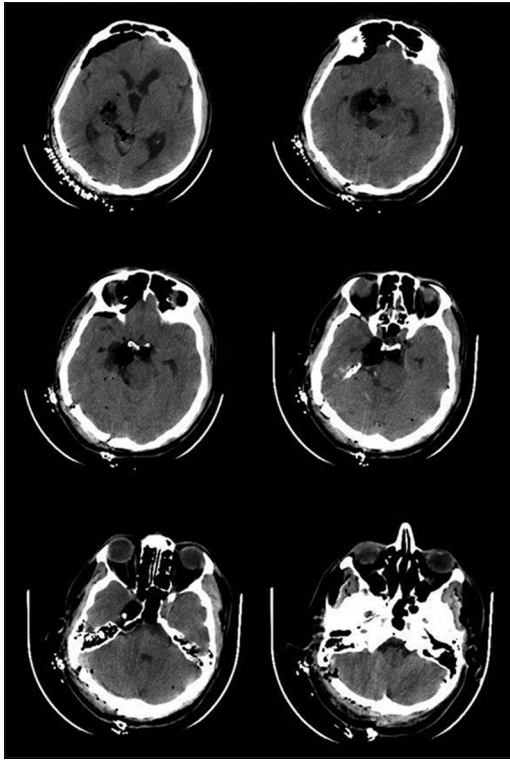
Postoperative computed tomography revealing gross total removal of the lesion
